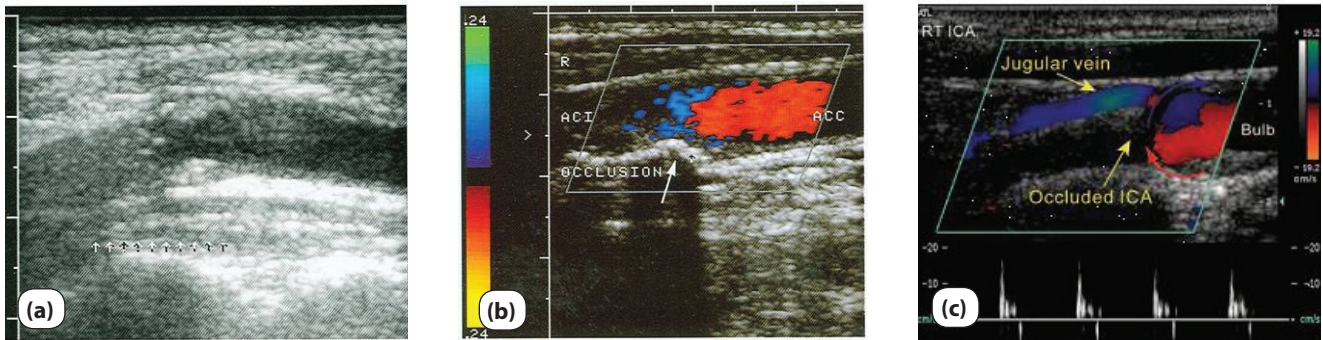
Occlusion of ICA. (a) In the case of an old occlusion, the occluded lumen can be well visualized in B-mode on account of the increased echogenicity. (b) In the case of a recently formed occlusion, the nonperfused lumen appears as a hypoechoic region in B-mode. The occlusion can only be detected by flow reversal using the color coding mode (arrow). (c) A biphasic Doppler signal can be recorded usually in the region of the reversed flow, just before the occluded segment (arrow).
